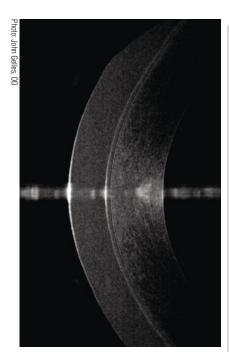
Specialty soft lens designs have a CT typically three to six times that of traditional hydrogel lenses.
